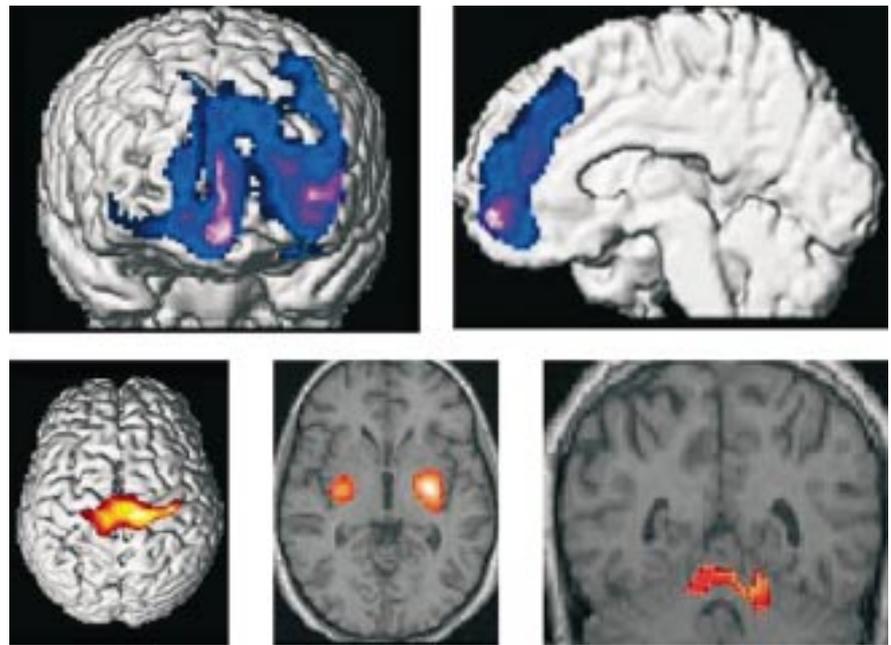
Results of the exclusive masking analysis showing a decrease of metabolism in a large prefrontal area (upper row, on the right), the right anterior cingulate and the right medial frontal cortices (upper row, on the left). This analysis also showed a relative increase of metabolism in primary motor cortices (lower row, on the left), in the rostral part of the striatum (lower row, on the middle), and in the vermis (lower row, on the right). Dysfunctional brain areas have been coregistrated to the patient's magnetic resonance imaging.
